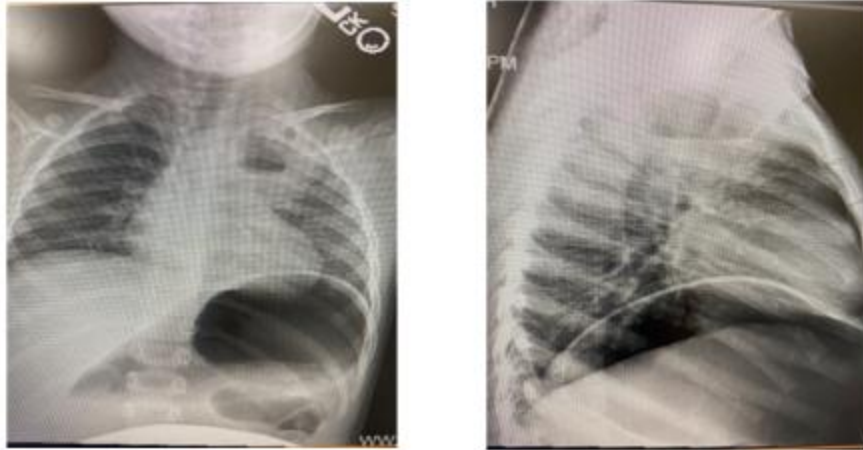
Plain radiograph of the patient's chest in AP and lateral views showing left upper lobe consolidation with lucency
